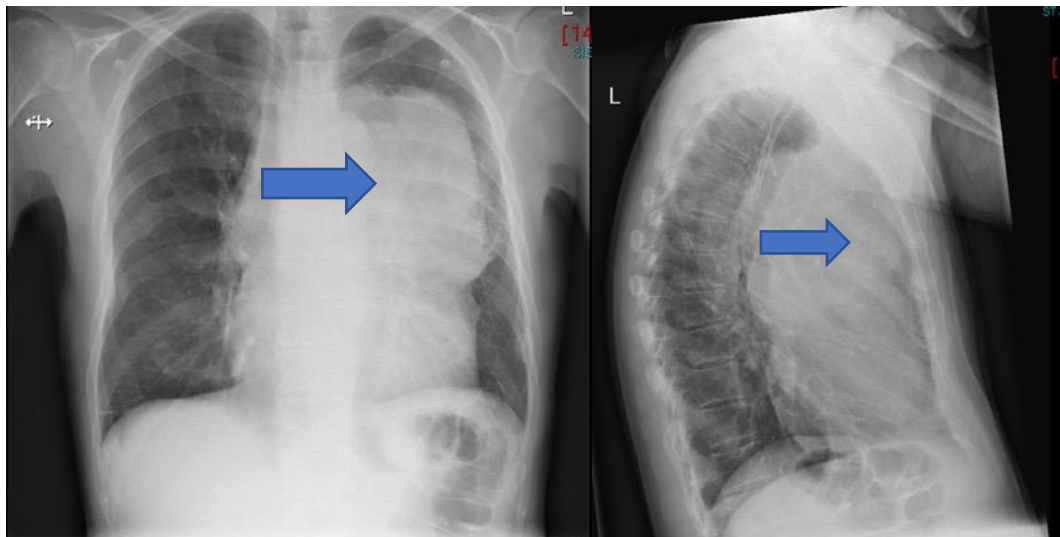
Germ cell tumour. Plain radiographs showing large left-sided mediastinal mass (blue arrow).
